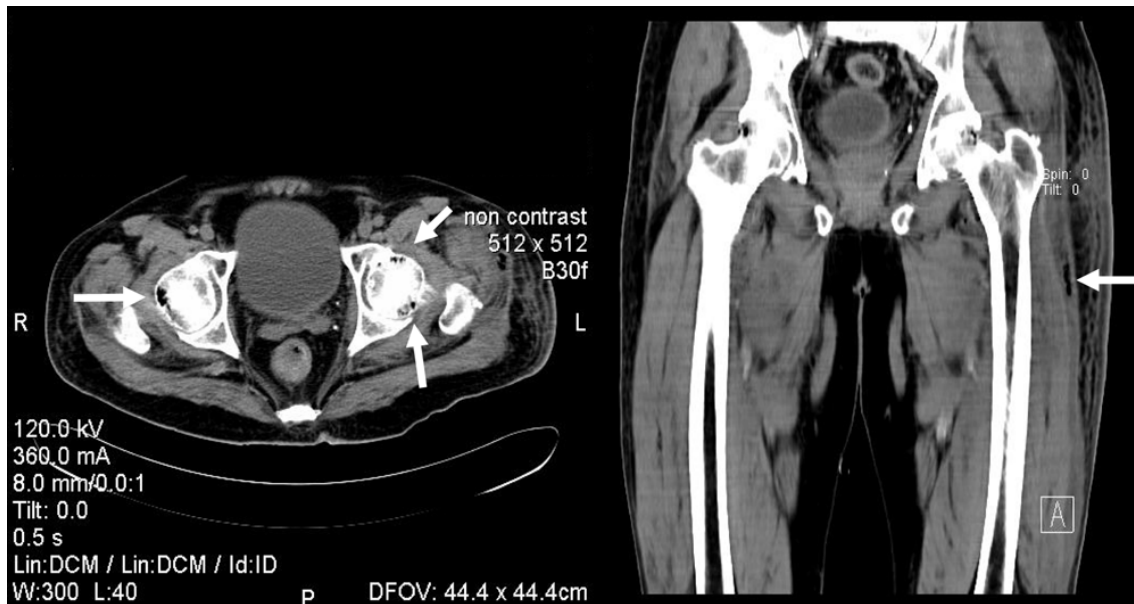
Computed tomography exhibited multiple air bubbles within the medullary parts of the femoral heads and thigh muscles (arrows), indicating gas-forming osteomyelitis and pyomyositis
